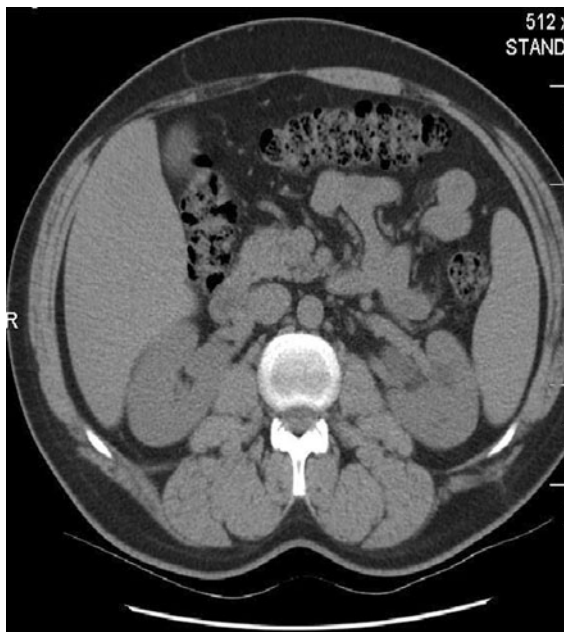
Computed tomography 2 years after the ureteral re-implantation
